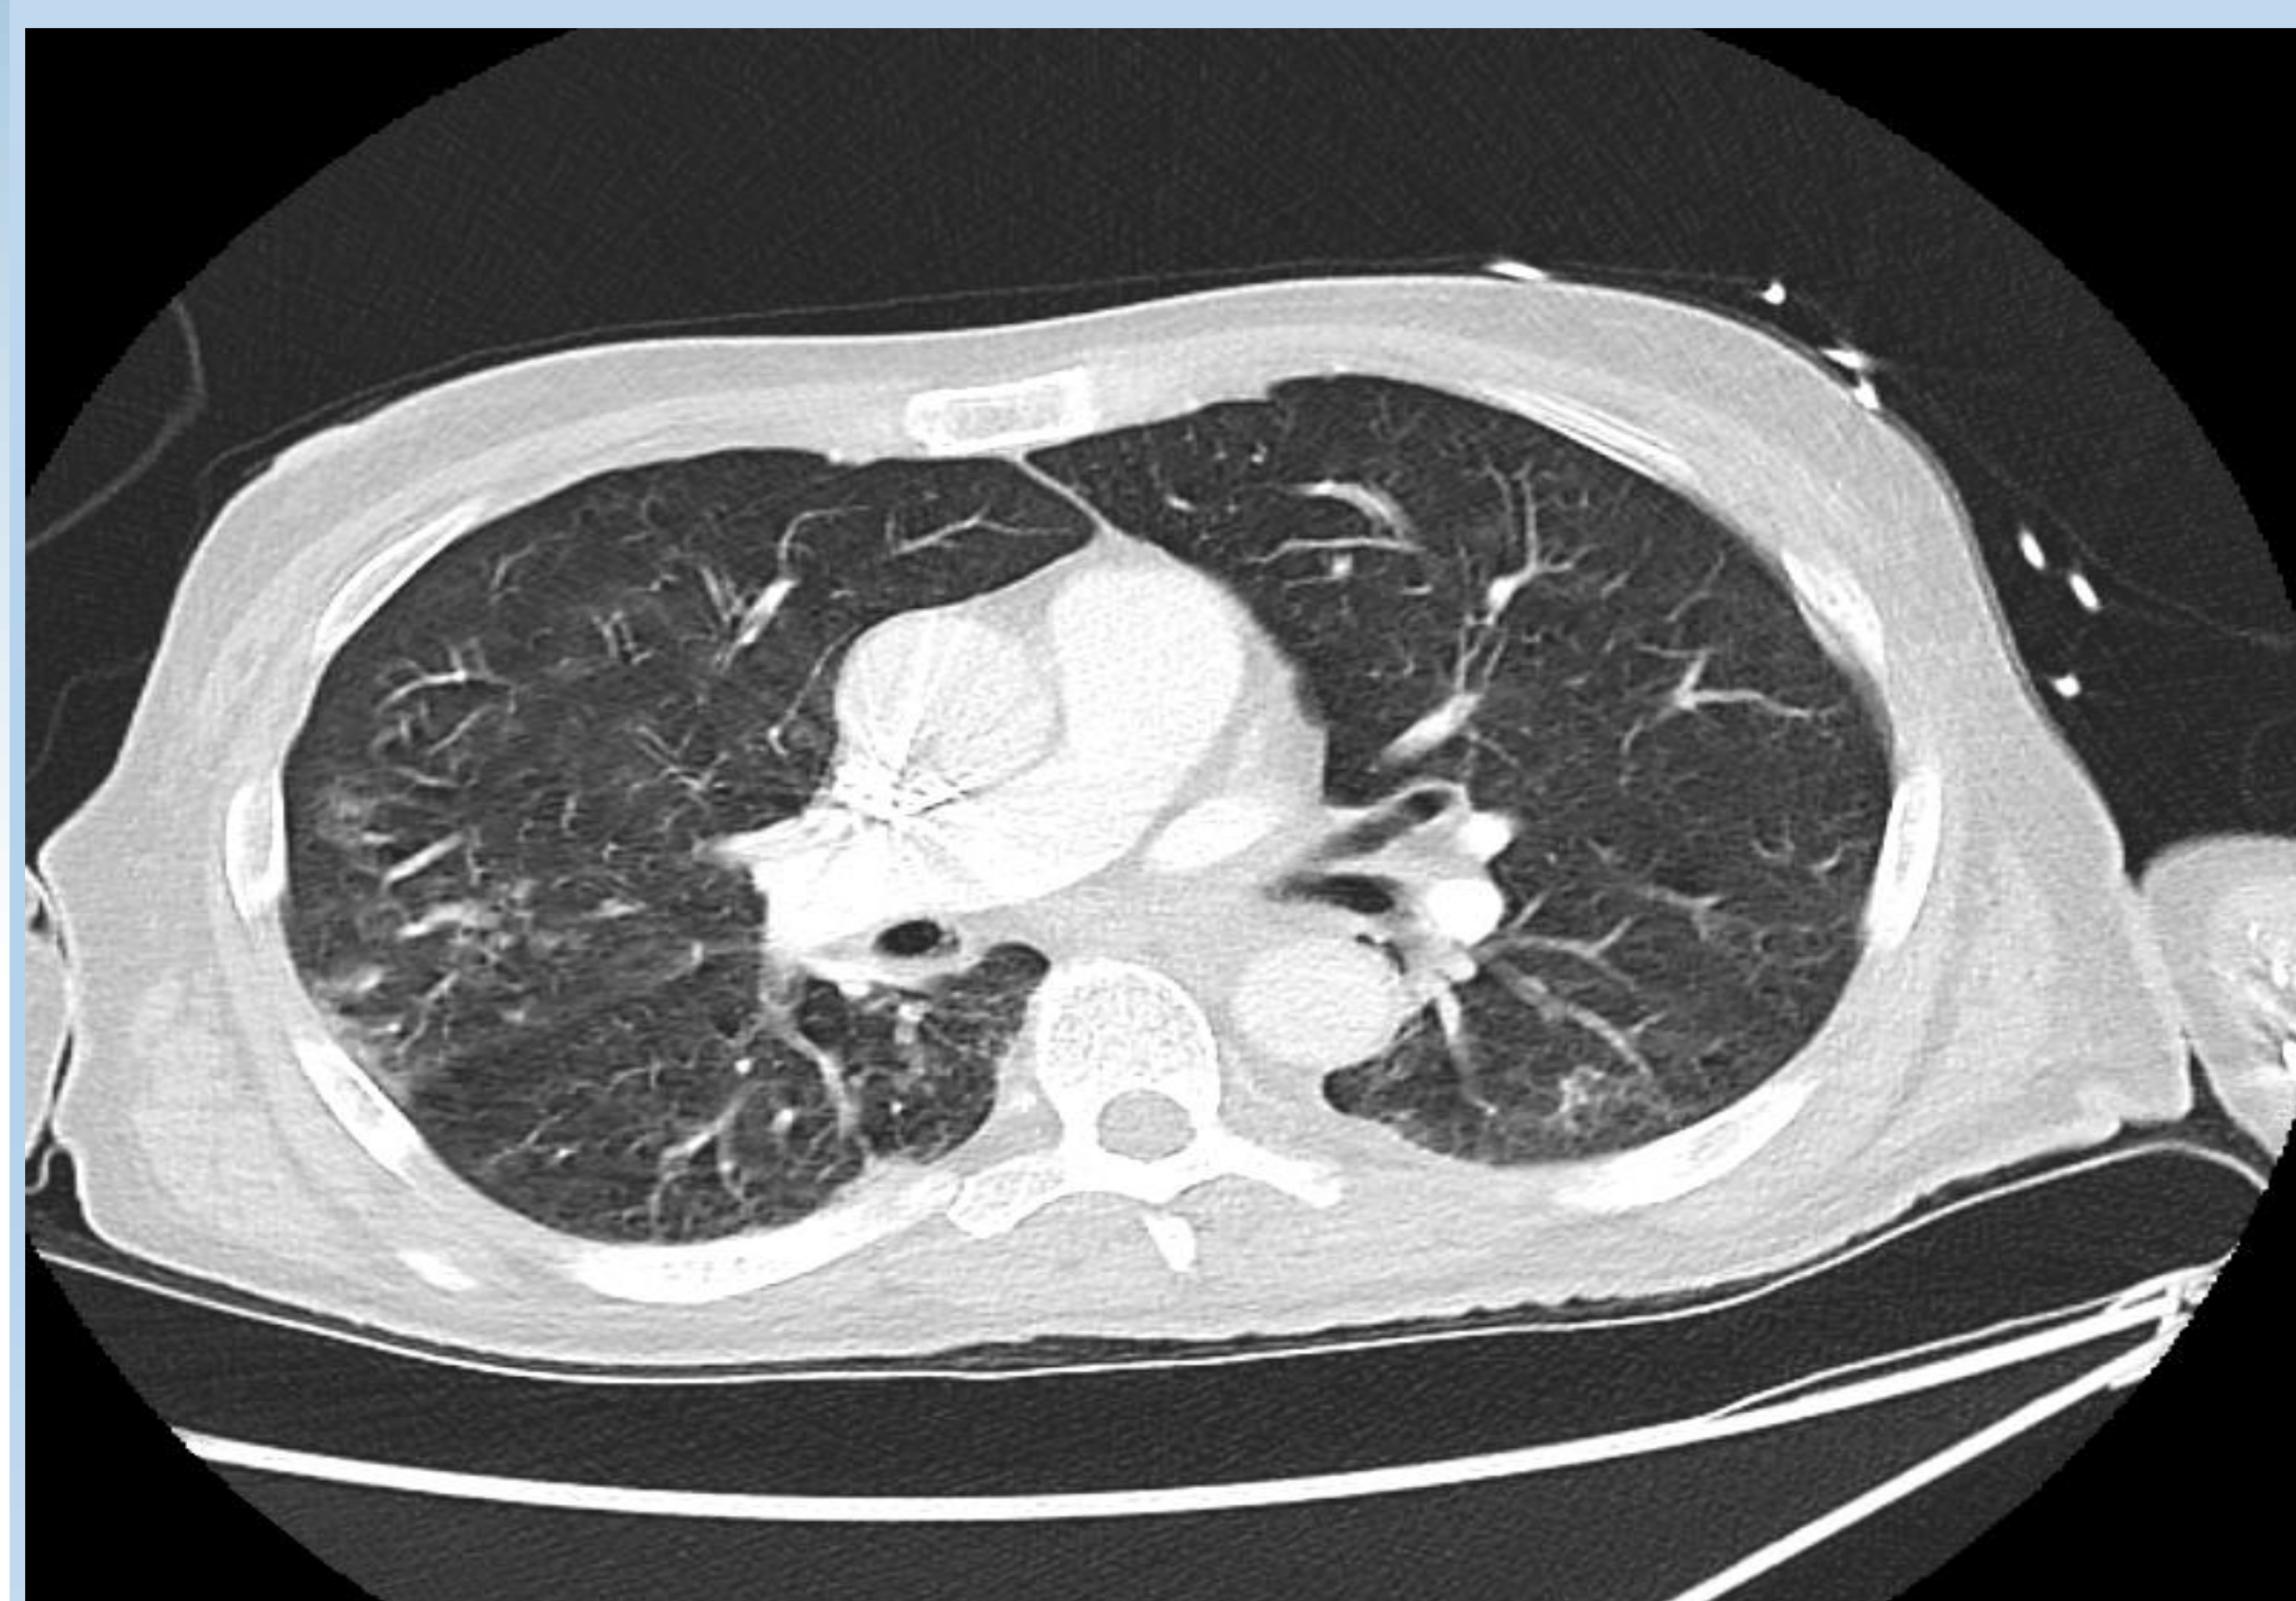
CT showing infiltrates bilaterally, in the bases compatible with multifocal pneumonia.
